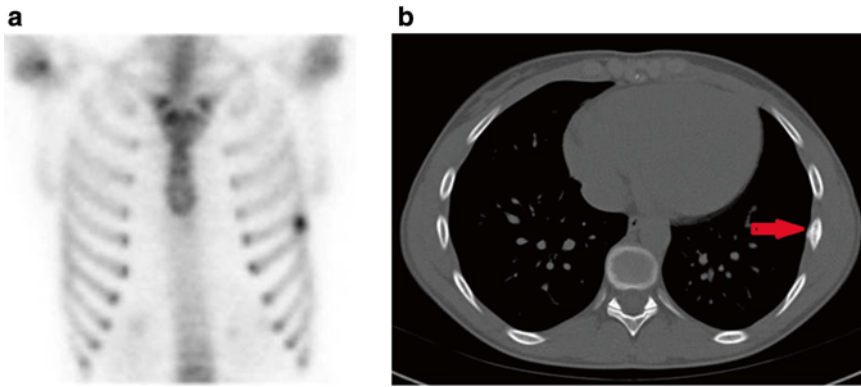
Bone scan (a) and axial CT scan (b) images demonstrating stress fracture of the left mid seventh rib. CT scan demonstrates fracture callus present
